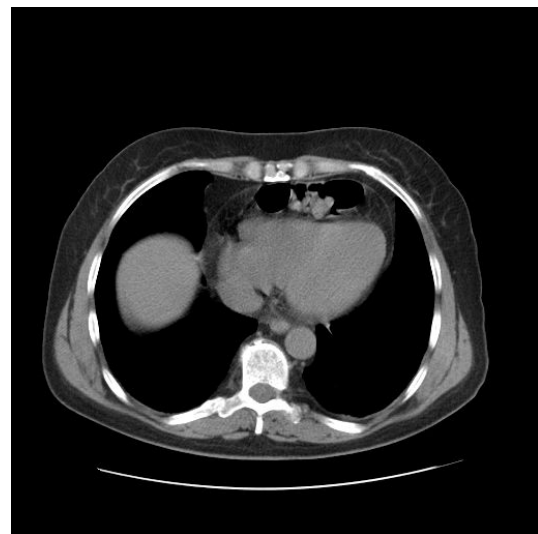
CT scan shows bowel in the pericardium.
